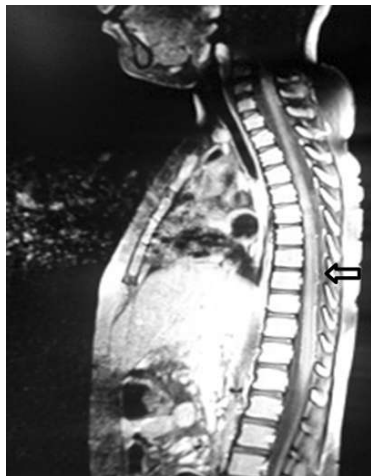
Post contrast sagittal MRI of dorsal spine showing enhancement of leptomeninges (arrow).
